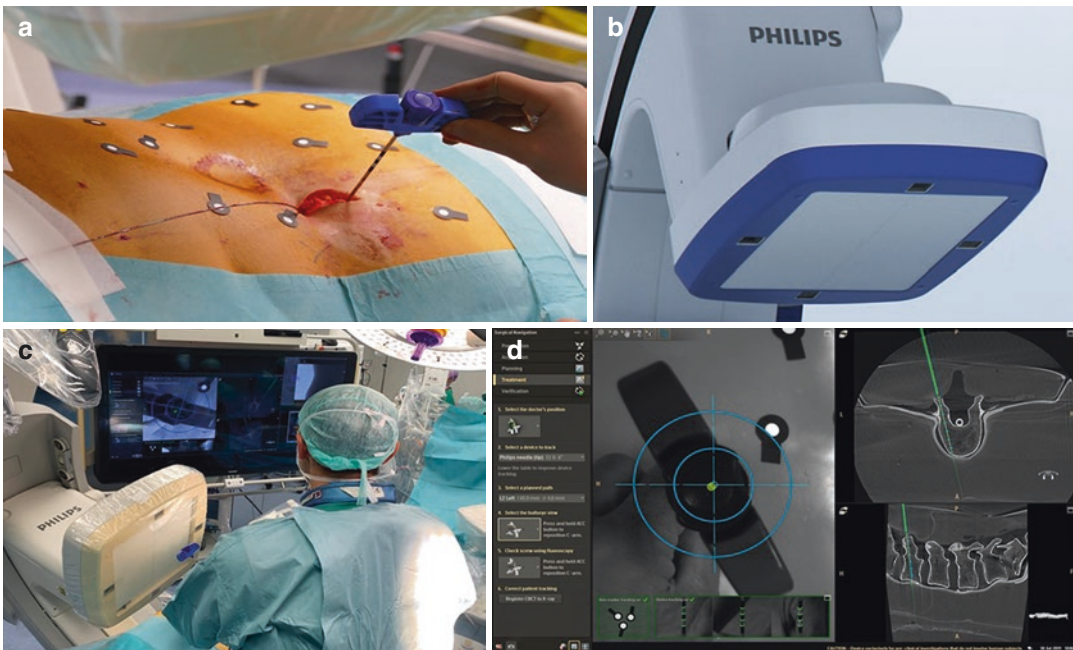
Augmented Reality (AR) (ClarifEye)-based navigation for spinal deformity. Video cameras integrated into X-ray detector frame cover (b) for tracking with non-invasive markers (a) placed on the patient's skin. Live display from the video cameras augmented with 3D volume
